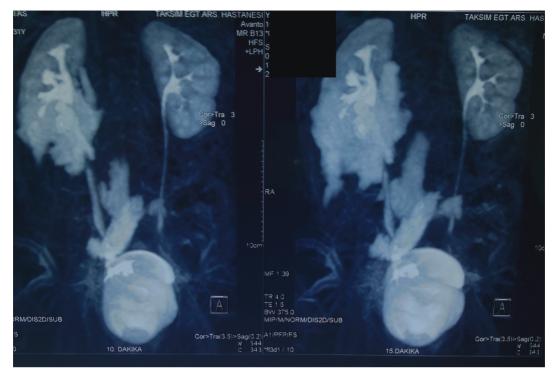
Gadolinium-enhanced MRI examination showing right hydronephrosis and contrast extravasation at the middle and proximal portions of the right ureter together with intraperitoneal extension of contrast media resembling cotton in appearance.
